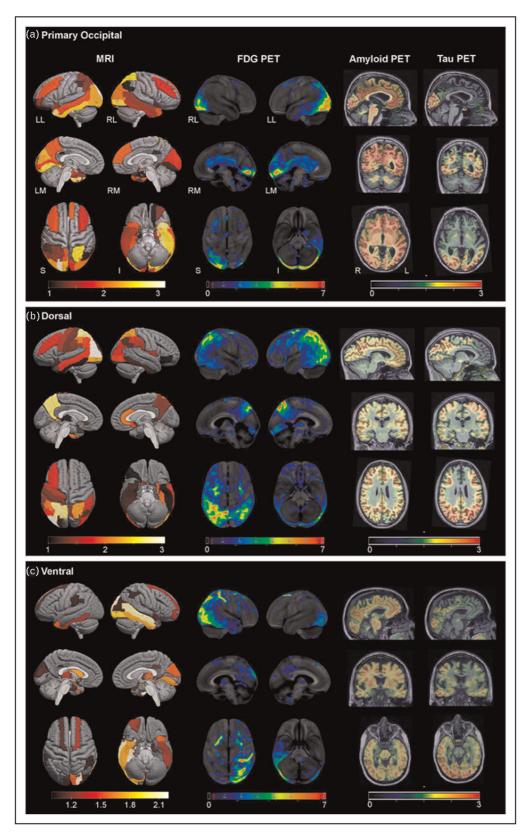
Neuroimaging features (Structural MRI on the left, fluorodeoxyglucose (FDG)-PET in the center, and amyloid- and tau-PET on the right) observed in the subvariants of posterior cortical atrophy: (A) primary occipital variant; (B) Dorsal variant; (C) Ventral variant. Reproduction from [20^{••}].
